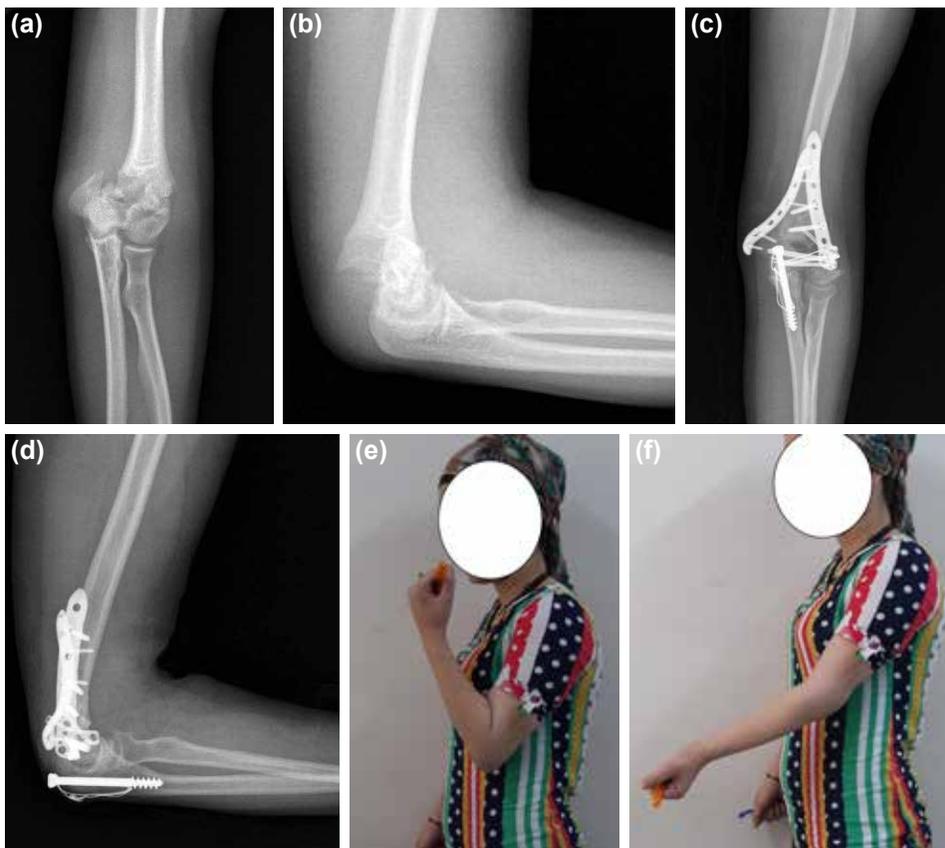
(a, b) Preoperative X-rays (anteroposterior and lateral views) of the elbow shows intra-articular fracture of distal distal humerus; (c, d) after parallel plate fixation using olecranon osteotomy approach, at 19 months of follow-up X-rays (anteroposterior and lateral views) shows fracture union; (e, f) functional view of the patient.
